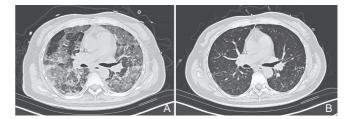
Chest CT images. (A) On the first day in the hospital, the CT images showed patchy high-density shadow, ground-glass opacity and consolidation with obscure margin. Air bronchogram appeared; (B) On the 24th day in the hospital, the CT images showed an obvious alleviation of the pulmonary infection.
